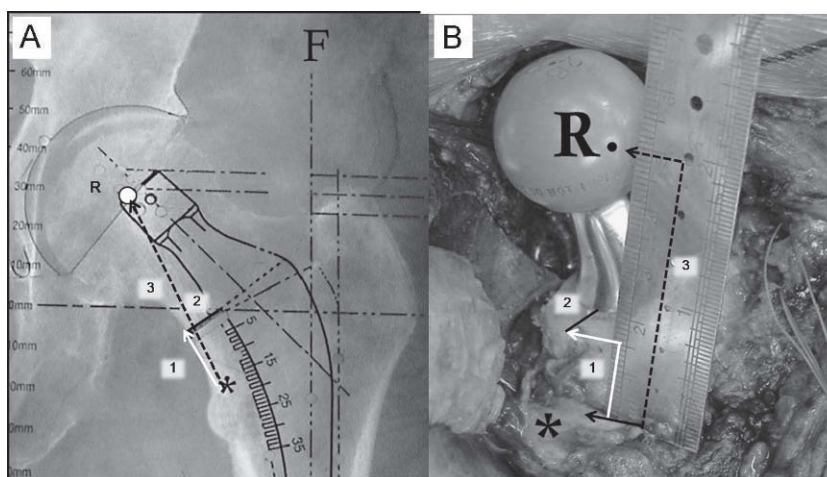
A) This radiograph shows how to calculate the reference distances for femoral component planning. 1: distance between the superior corner of the lesser trochanter and femoral neck osteotomy site; 2: distance between the medial femoral osteotomy and stem; 3: distance between the upper corner of the lesser trochanter and the centre of rotation of the prosthetic head. B) Intraoperative image showing how to reproduce the baseline radiographic measurements of the patient's femur, after insertion of trial components. Following the identification of the femoral head centre of rotation, the proximal angle of the lesser trochanter and the medial border of cervical osteotomy, a sterile ruler is used to calculate the distances previously described (6A). *: Proximal lesser trochanter; F: femoral shaft axis; A: centre of rotation of the prosthetic head.
